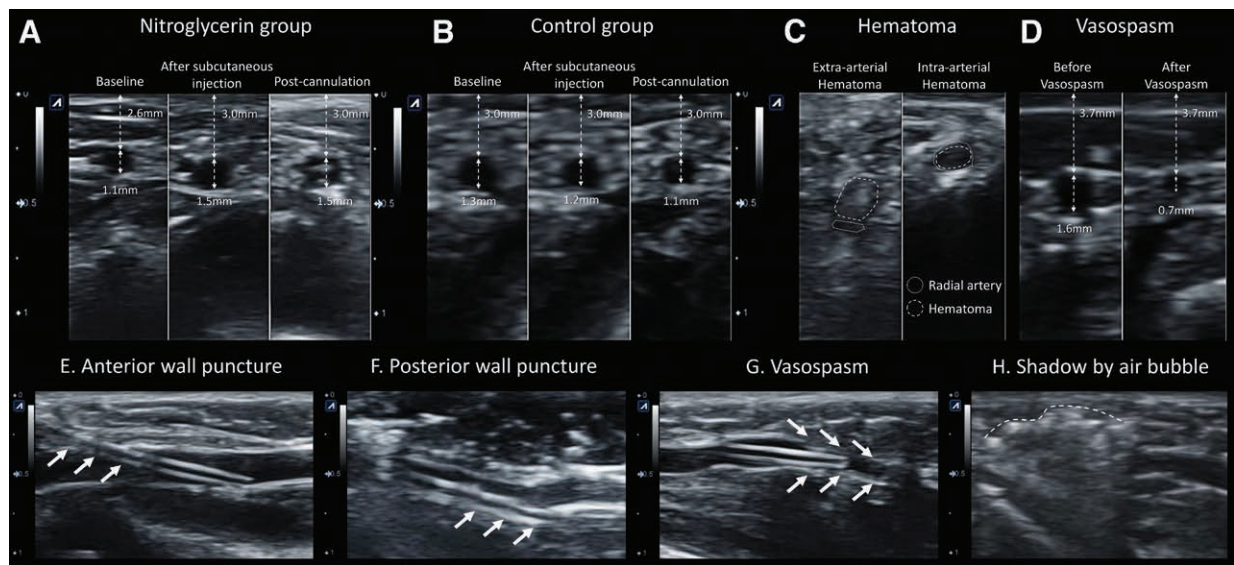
Ultrasound images of the radial artery cannulation. Examples of changes in the diameter and depth of the radial artery after subcutaneous injection and postcannulation. (A) A 3-month-old infant in the nitroglycerin group showed significant vasodilation after subcutaneous injection and maintained the increased diameter after cannulation. (B) A 1-month-old infant in the control group showed no change in the radial arterial diameter after subcutaneous injection. (C) Hematomas and (D) vasospasm after failed attempt. Long-axis images of (E) anterior arterial wall puncture, (F) posterior arterial wall puncture, (G) vasospasm proximal to the catheter tip, and (H) shadow by air bubble due to subcutaneous injection.
